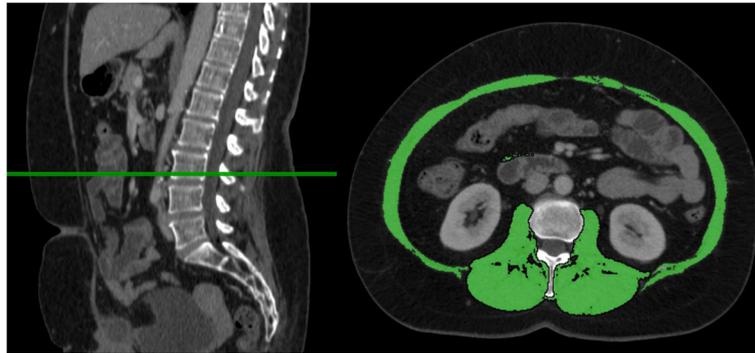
Measurement of lean body mass area in an axial CT slice obtained at the L3 level
